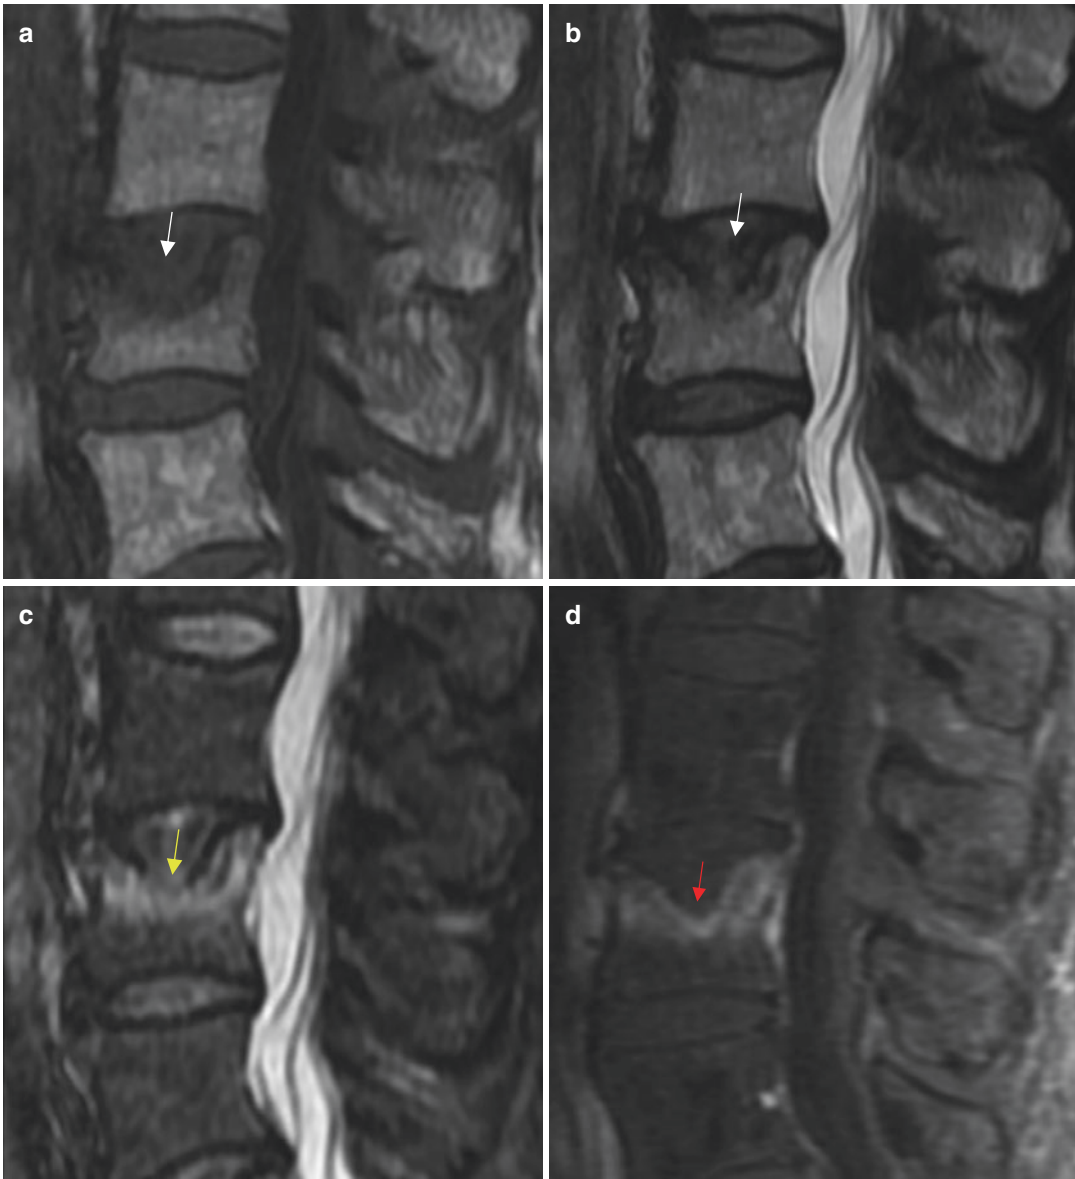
(a) Sagittal T1- and (b) T2-weighted images demonstrate a large defect in the superior endplate of L3 with fairly similar signal characteristics as the L2-L3 disc, consistent with a Schmorl's node (white arrows). (c) Sagittal STIR image and (d) corresponding sagittal
